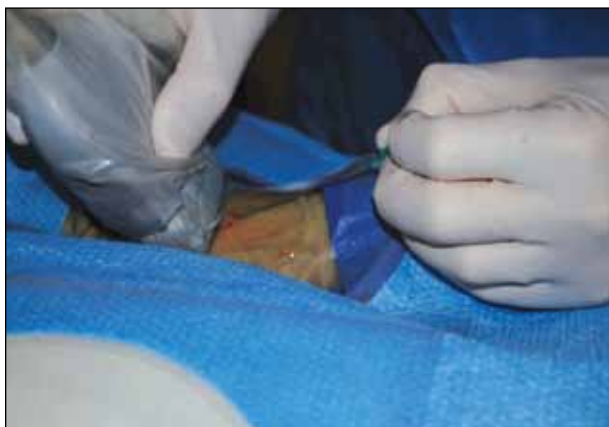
Ultrasound-guided access to the radial artery with a 21-gauge micropuncture needle.
